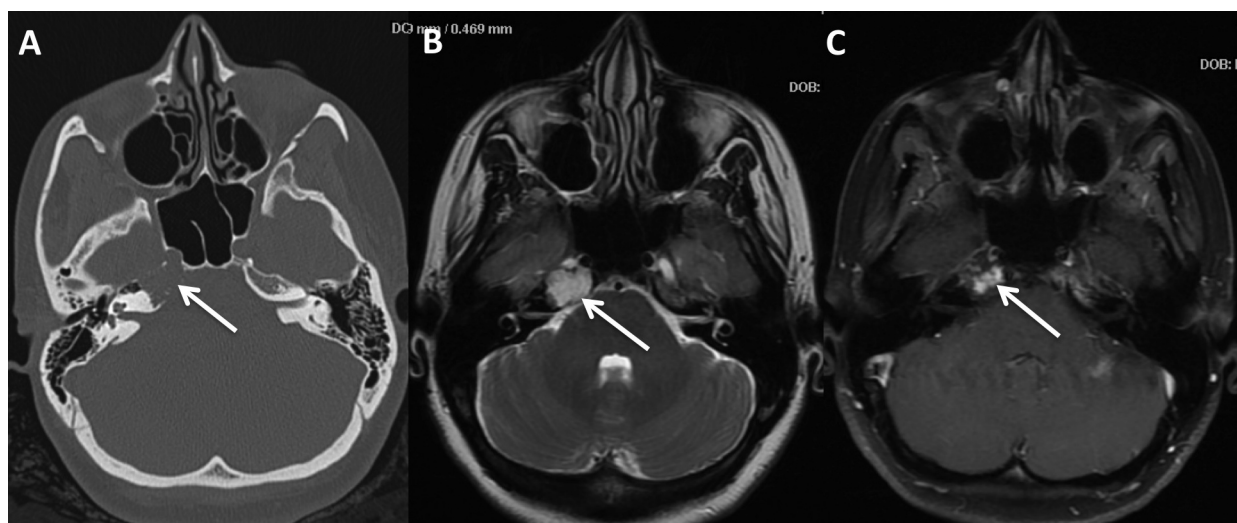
39-year-old female with skull base IPEH. (2A) Axial unenhanced head CT in bone window shows an expansile mass in the right petrous apex (arrow) with osseous erosion. (2B,C) Axial T2- and post-contrast fat saturated T1-weighted imaging demonstrates the mass to be heterogeneous, well demarcated, and avidly enhancing (arrows).
